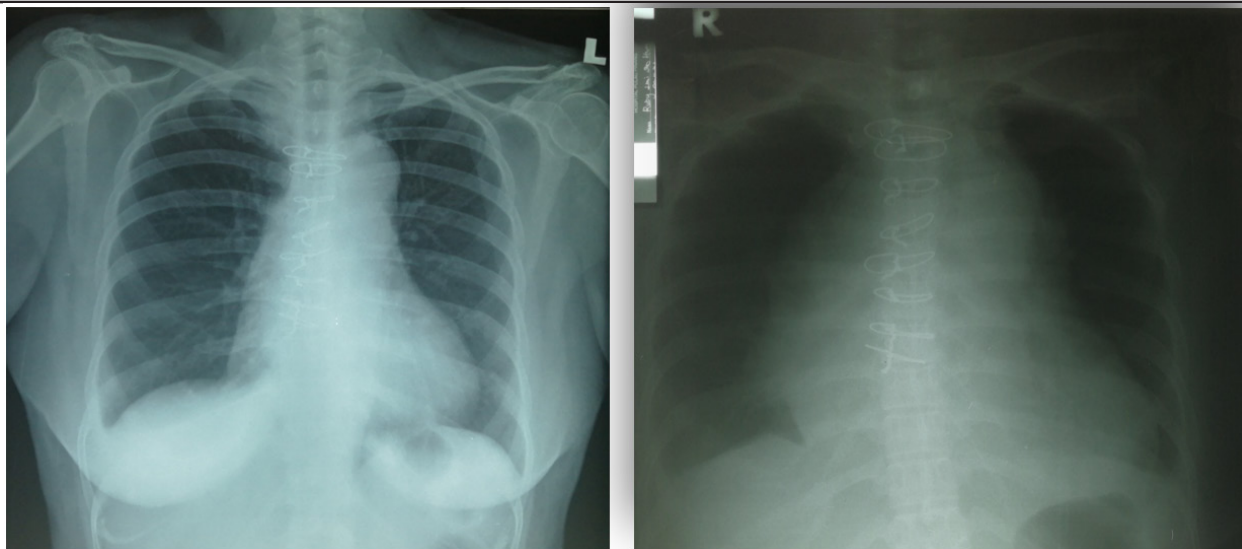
a. Chest Xray post Stanford A dissection repair; b. Chest Xray showed widened mediastinum upon admission.
